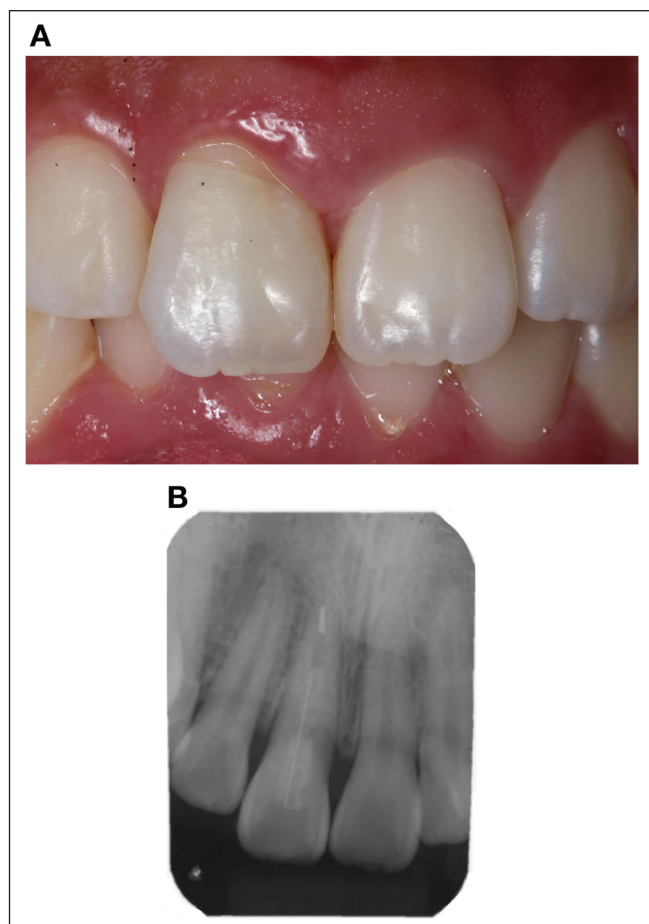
Follow-up at 12 months. (A) Close-up front view showing subtle fracture line; (B) Periapical radiography attesting normality of the periapical tissues and good adaptation of the fiberglass post.
